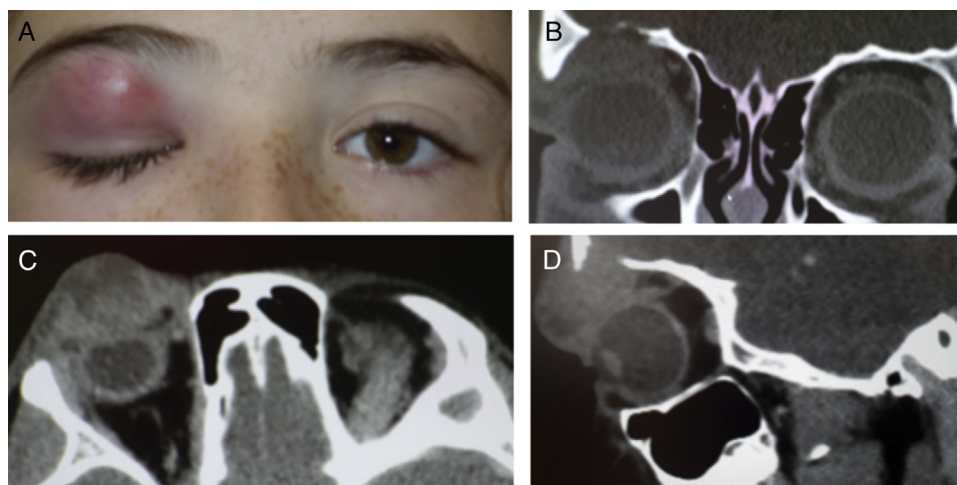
Presurgery clinic findings. (A) Clinic photography of the patient with mechanical blepharoptosis caused by soft, inflammatory-like lesion in the upper eyelid of the right eye. (B) Coronal CT image showing the lesion in the right orbital region producing bone destruction in the orbital roof. (C and D) Axial and sagittal image, respectively, of CT showing extraconal heterogeneous lesion.
